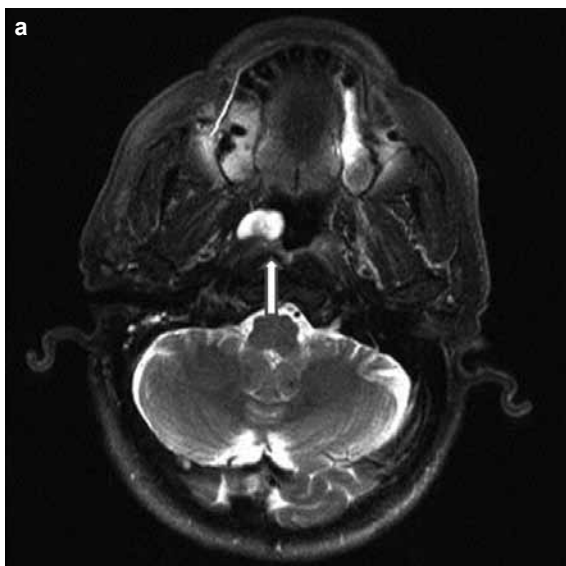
a, b. Axial and coronal MRI images showing a mass in the right side of the nasopharynx (arrow)
